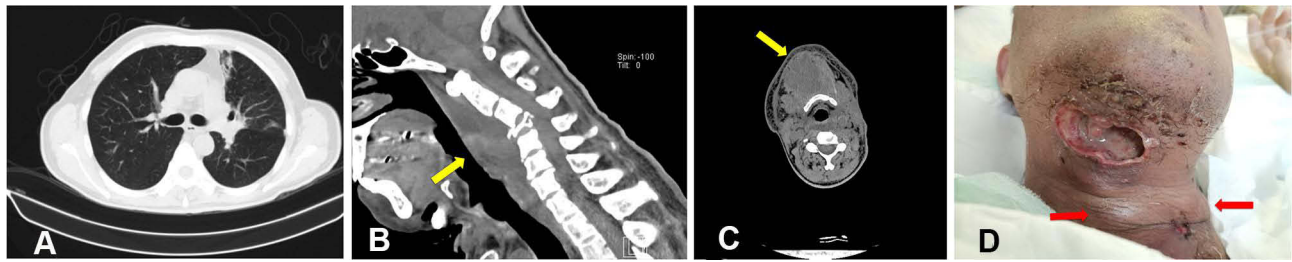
Computed tomography findings. Chest: The pulmonary lesions were markedly improved after 3 weeks of antifungal therapy (A). Neck: An abscess in the posterior pharyngeal wall, a fracture of the 4th cervical vertebra (B), and new mass on the right side of the neck (C) were found. The abscess disseminated to the lower right neck and sternum (D).
